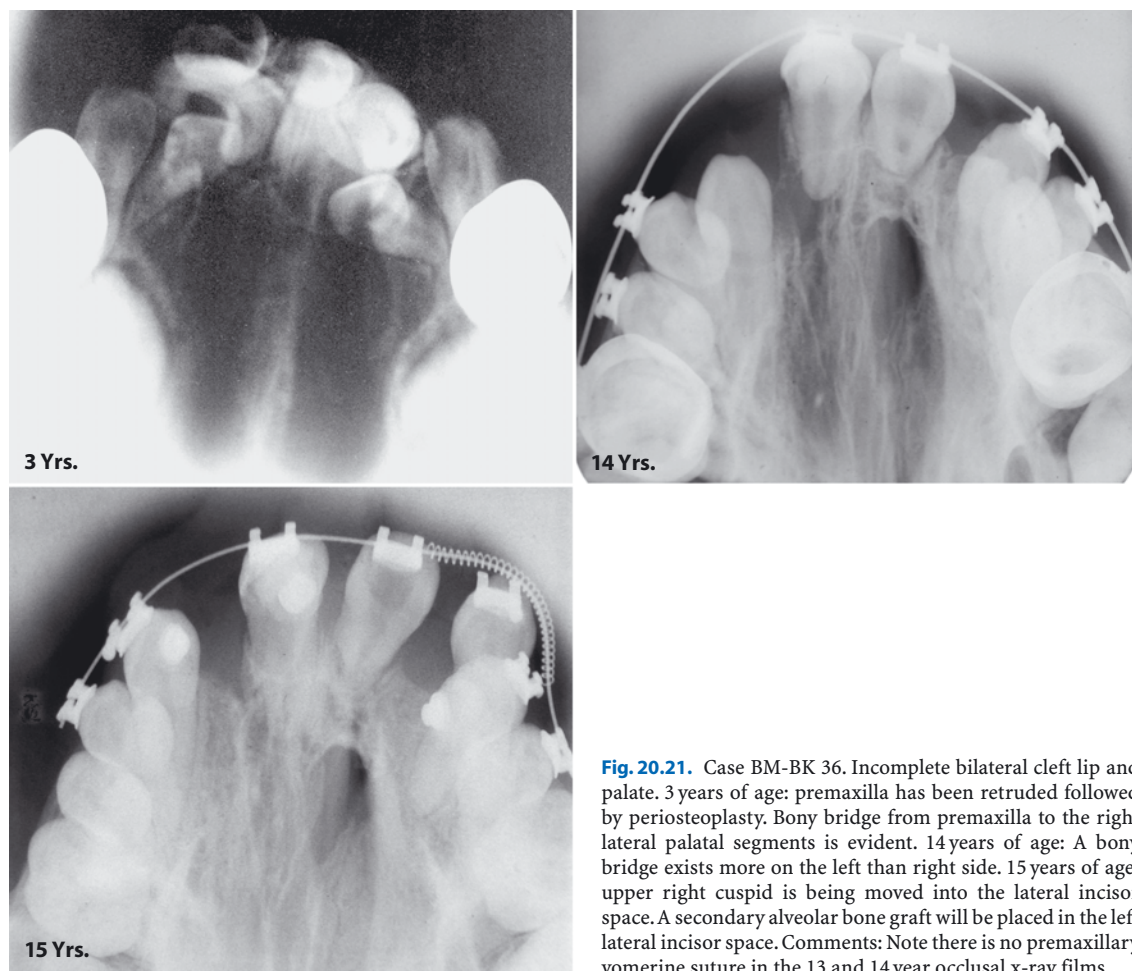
Case BM-BK 36. Incomplete bilateral cleft lip and palate. 3 years of age: premaxilla has been retruded followed by periosteoplasty. Bony bridge from premaxilla to the right lateral palatal segments is evident. 14 years of age: A bony bridge exists more on the left than right side. 15 years of age: upper right cuspid is being moved into the lateral incisor space. A secondary alveolar bone graft will be placed in the left lateral incisor space. Comments: Note there is no premaxillary vomerine suture in the 13 and 14 year occlusal x-ray films
